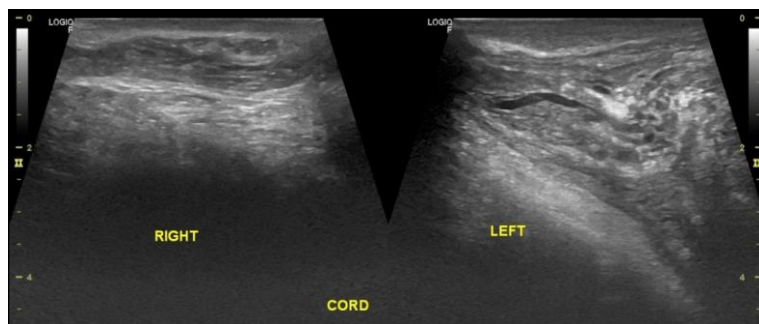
Spermatic cord grey scale ultrasound images. Right cord shows normal appearance as compared to the left which is thickened and echogenic with flow voids.
